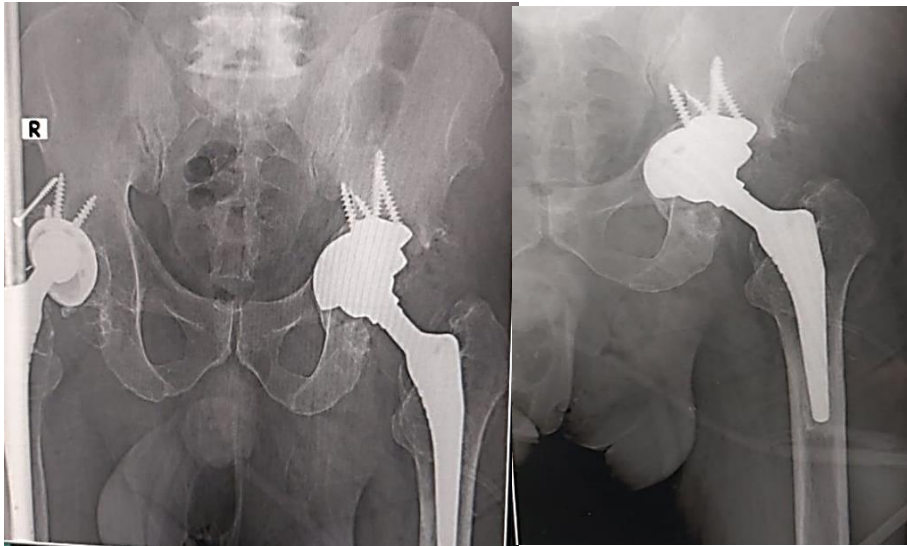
follow up x-ray after 6 weeks
